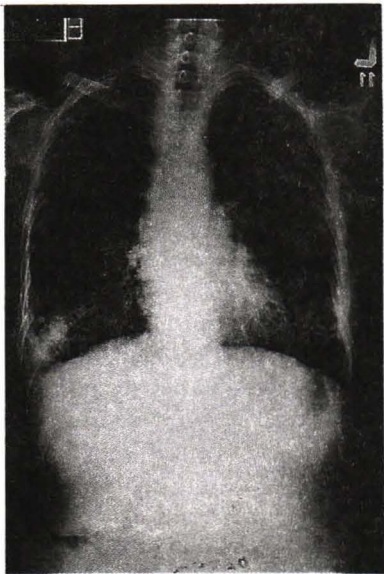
Chest radiograph on presentation of case 1; showing diffuse reticulonodular shadowing, hyperinflation and cystic opacities in both lower lungs. There is a fungal ball at the right lower lobe.
